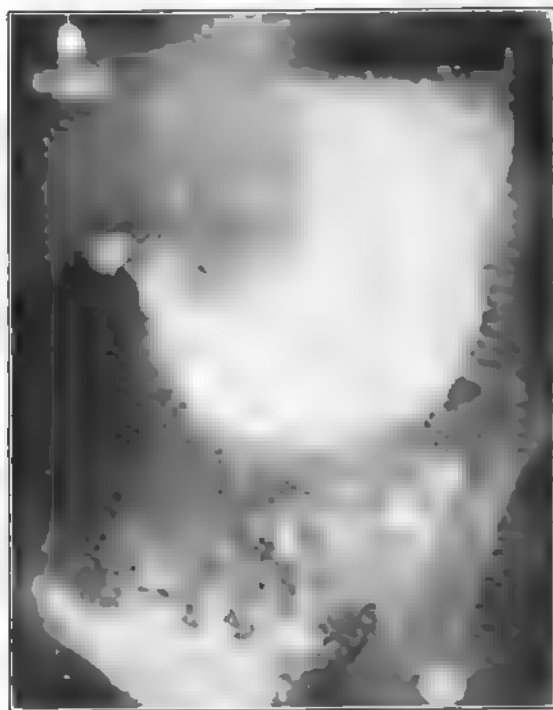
(Case No. A83,327; X-ray No. 20,934.) Male, aged fifty-five. Filling defect or irregularity of the pars pylorica. Residue after six hours. Exploration: Carcinoma of the stomach.
